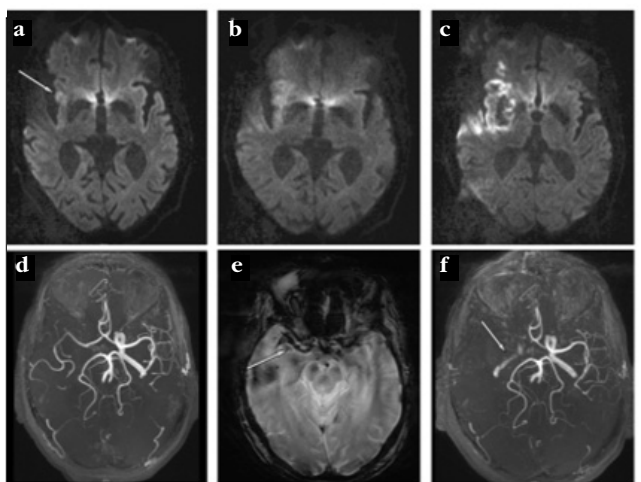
Imaging findings (MRI, 3 tesla TimTrio, Siemens) before thrombolysis (a+d), immediately after clinical worsening (b+e) and the following day (c+f). a: DWI hyperintensity on admission. b: Enlargement of the DWI hyperintensity. c: Known enlargement of DWI hyperintensity and hemorrhagic transformation. d: MR-A shows tandem occlusion of ICA and one M2 segment. e: T2* shows new MCA main-stem-clot. (MRA is of poor quality due to movement artefacts.) f: MR-A shows partial recanalisation of ICA and MCA-main-stem-occlusion
